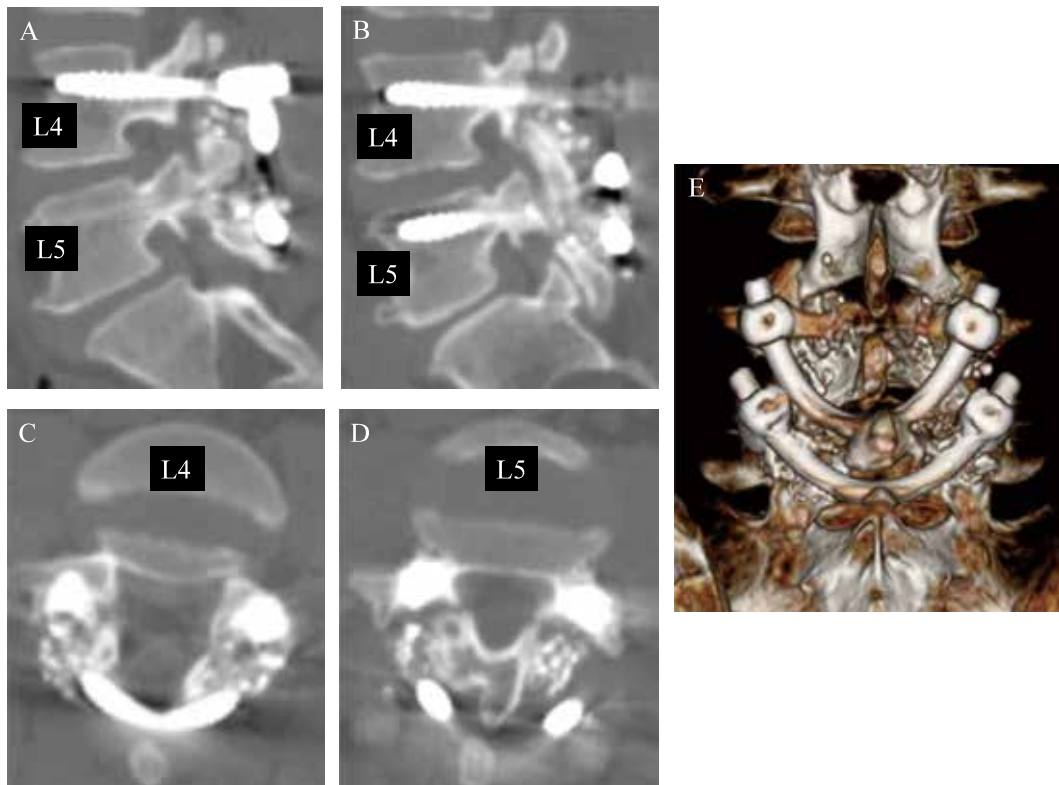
Postoperative right para-sagittal (A), left para-sagittal (B), axial (C, D) and three-dimensional computed tomography scans (E) at L4 and L5 showing packing of cancellous bone around the pars defects.
